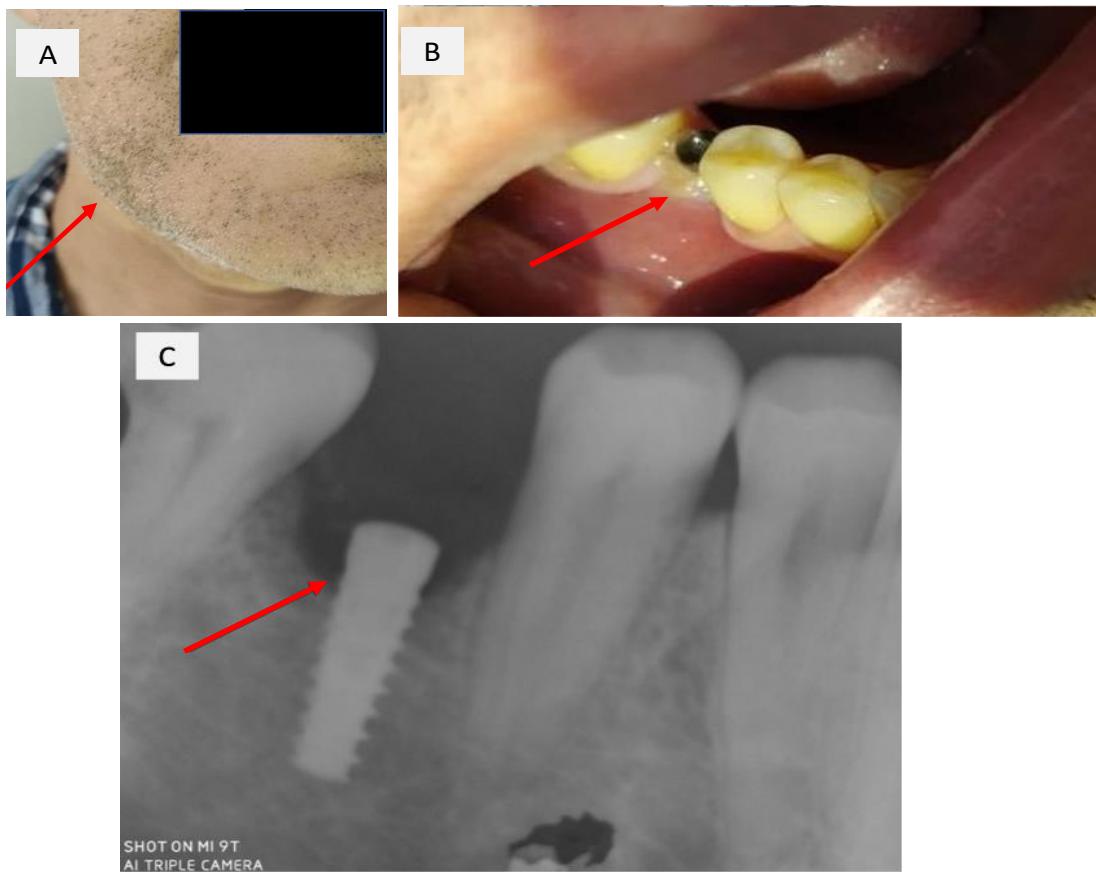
Images obtained at the day the patient sought for attendant reporting infection symptoms. A: Edema caused by infection; B: Periodontal fistula in the gingival tissue; C: Radiography from implant plus healing cap. The arrow indicates the bone loss promoting the exhibition of implant surface.
